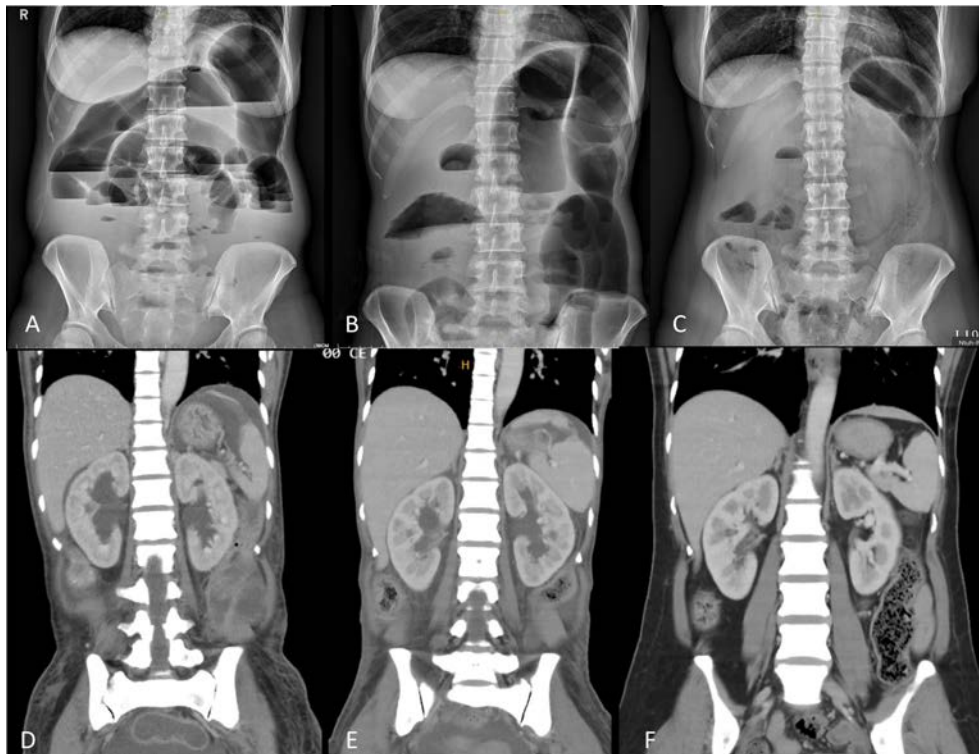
Serial standing abdominal plain films (A–C) and coronal computer tomography (CT) of the abdomen (D–F) of this patient. A (2023/10/10): Prior to induction therapy with cyclophosphamide (CYC) and belimumab (BEL), there is marked evidence of severe ileus, manifesting as pronounced bowel distention and air-fluid levels; B (2024/04/01): After four CYC + BEL cycles, improvement in ileus is noted, with decreased but persistent bowel dilatation; C (2025/08/28): Post three cycles of obinutuzumab, there is marked resolution of ileus, with normalization of bowel gas pattern and absence of distended loops, indicating substantial clinical improvement. D (2023/10/11): Initial CT scan reveals grade 4 bilateral hydronephrosis; E (2024/04/11): After four CYC + BEL cycles, there is improvement to grade 3 hydronephrosis bilaterally; F (2025/01/16): Following one cycle of obinutuzumab, imaging demonstrates near-complete resolution: Grade 1 hydronephrosis on the right and grade 0 (normal) on the left.
